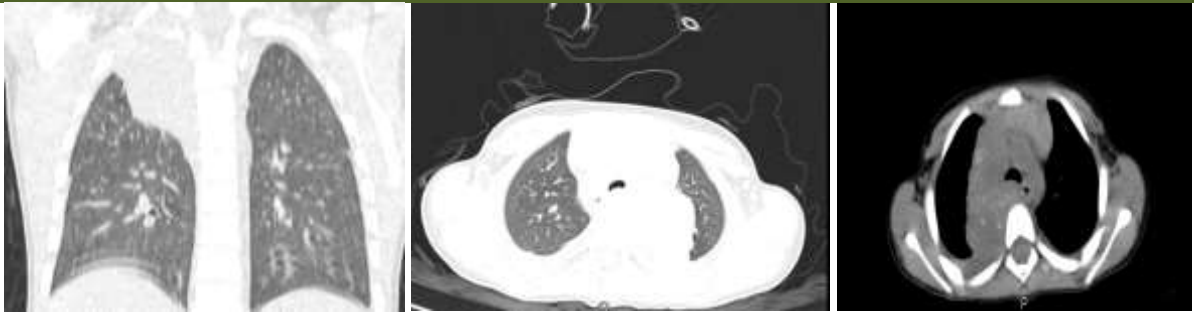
Thoracic CT scan parenchymal and mediastinal window C- shows an isodense process occupying the posterior mediastinum, seat of calcifications
